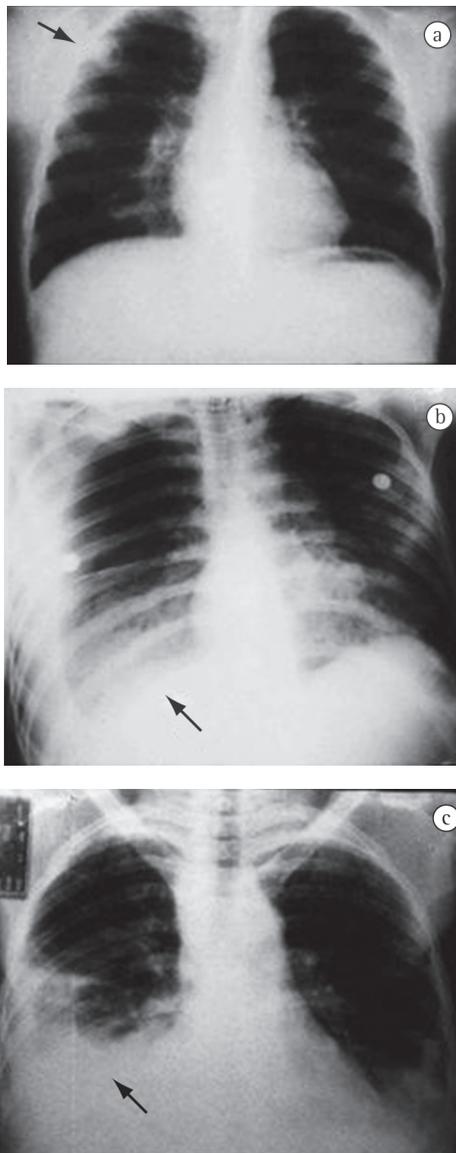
Chest X-rays selected from among the cases: a) cavity with well-defined borders adjacent to the pleura in the right upper lobe; b) extensive alveolar opacity with air bronchogram in the right lower lobe; and c) alveolar opacities in the lower lobes, with pleural effusion on the right.
